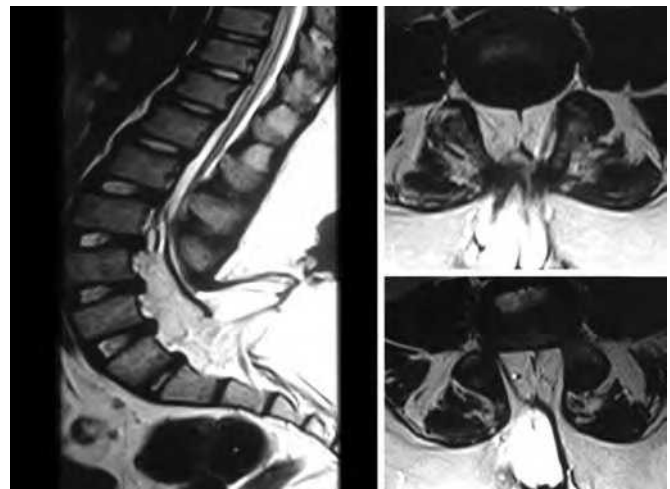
The magnetic resonance imaging scan shows a lipomyelomeningocele with spina bifida and tethered filum.
